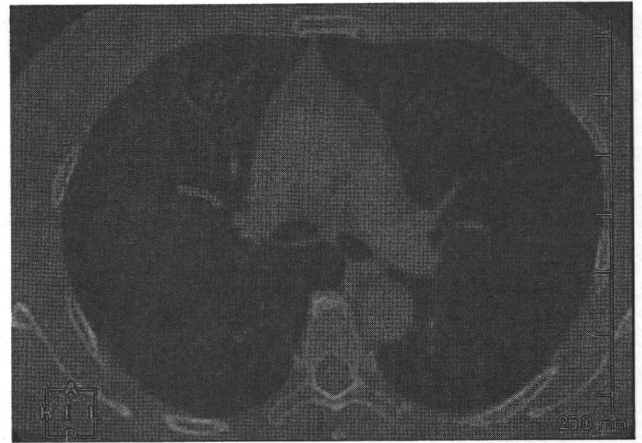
Tracking root (gray line) of a subsegmental vein on a CT image
